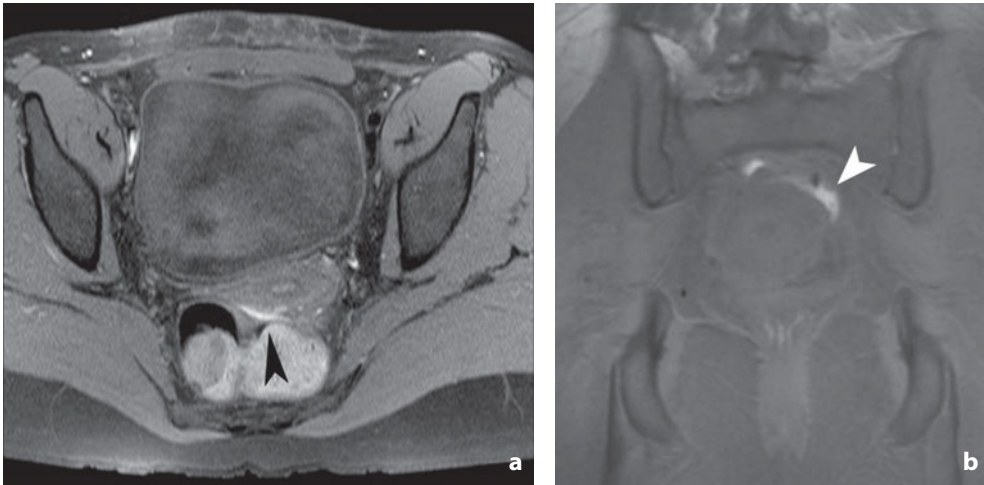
Magnetic resonance. Peritoneal endometriosis. Axial (a) and coronal (b) T1-weighted image with fat signal suppression show endometriosis with laminar appearance (arrowhead)
